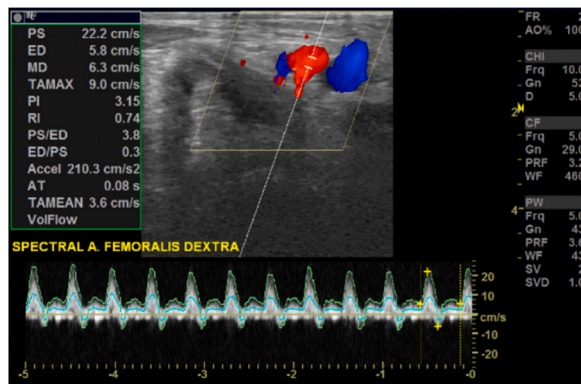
USG colored Doppler of lower extremity.
